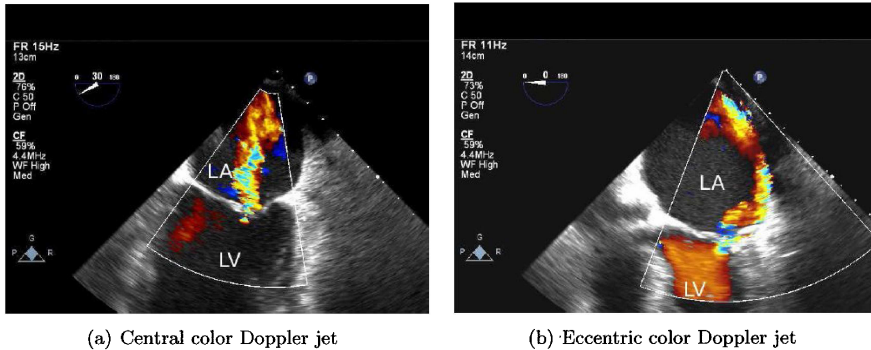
(a) Echocardiographic image of central regurgitant jet flowing from the left ventricle (LV) to the left atrium (LA). Colors denote different flow velocities. (b) Echocardiographic image of eccentric regurgitant jet, hugging the walls of the left atrium (LA) known as the Coanda effect.
